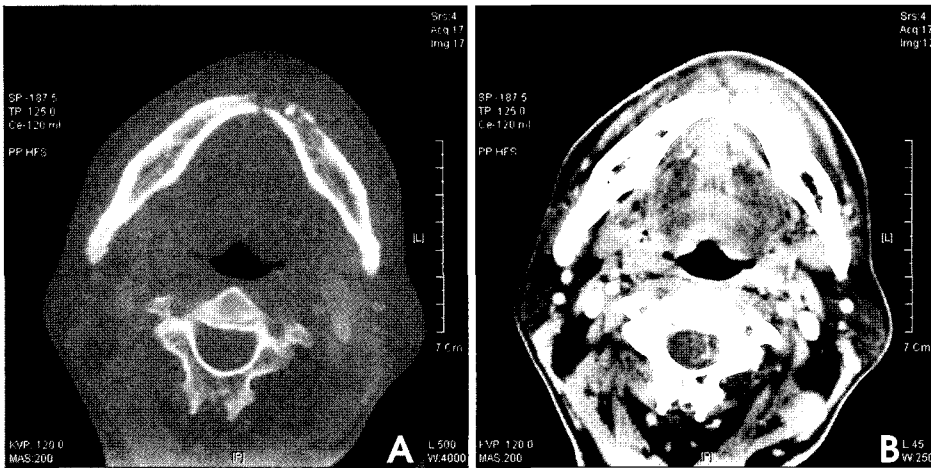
Bone-window (A) and soft tissue-window (B) axial CT scans showing perforation of the labial cortical plate of the mandible and an inhomogeneous mass extending into adjacent soft tissues.
